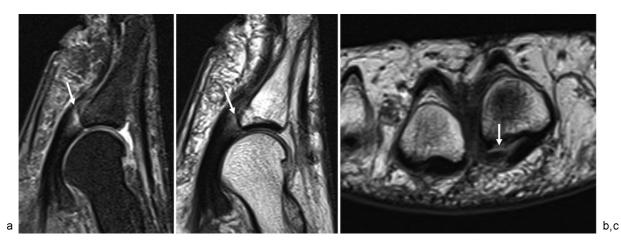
A 65-year-old woman presents with persistent and unchanged pain 11 months post second web space Morton neuroma excision. (a) Sagittal fat-suppressed proton-density (PD), (b) sagittal PD, and (c) short-axis T2 MR images of the second MTP joint demonstrate nonretracted tear of the lateral plantar plate at the proximal phalangeal insertion (arrows).
